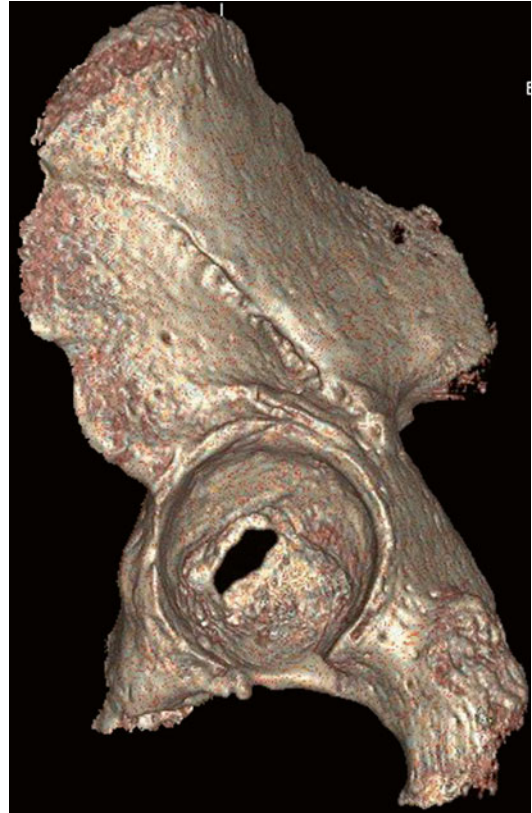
CT scan 3D reconstruction
